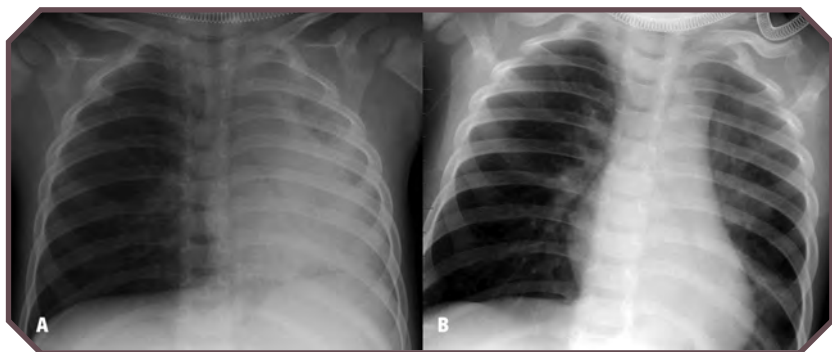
Atelectasis in a 2-year-old girl with shortness of breath. A. Frontal chest radiograph shows loss of left lung volume and shift of mediastinum from left to right. B. Frontal chest radiograph obtained 4 hours later demonstrates near-complete resolution of findings, consistent with resolved atelectasis.
